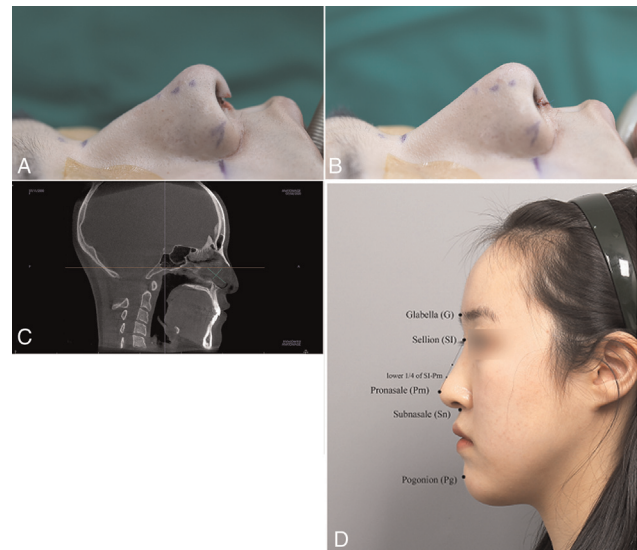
(A) When the septal extension graft and tip work are performed without an implant, a depression occurs in the line from the dorsum to the tip, and this could be solved by autologous septal cartilage. (B) A picture after a septal gap graft. Excessive supratip depression was resolved, resulting in a smooth line. (C) Preoperative CT scan. The amount of septal cartilage can be predicted through CT scan before surgery, and septal gap graft was performed when the length of the major axis and minor axis of septal cartilage was more than 25×30 mm. (D) The points and measured indices. Glabella (G), the most prominent point in the midline between the brows; Sellion (SI), the deepest point of the nasofrontal angle at the intersection of forehead slope and nasal slope; Pronasale (Pmn), the most prominent point on the nasal tip; Subnasale (Sn), the point beneath the nose where the columella merges with the upper lip in the midsagittal plane; and Pogonion (Pg), the most anterior point on the chin. Indices used. Supratip Depression Index, ("A"/SI-Pmn) $\times 100$ (%); Nasal Tip Projection Index, (Sn-Pmn/G-Pg) $\times 100$ (%); "A," distance between the skin and the lower quarter of the straight-line connecting SI and Pmn.
